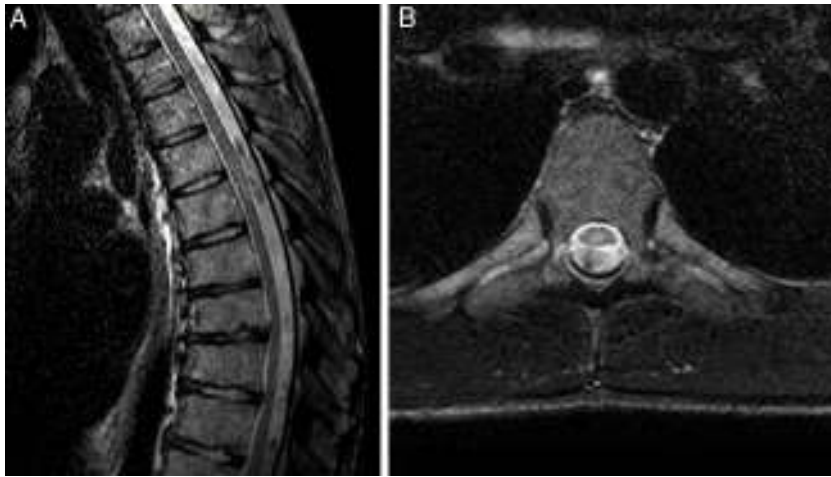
Axial (A) and transversal (B) T2-weighted MRI sequences of the dorsal column showing hyperintensities in the centre of the spinal cord at T5-T6 and no mass effect, uptake, or oedema, which is compatible with residual signs of myelomalacia.
